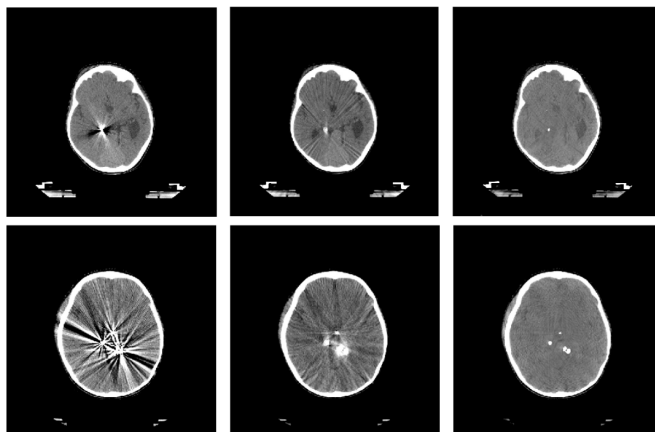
Examples of processing real corrupted CT scan with intensities in brain window (40+-80 HU). From left to right: original image, Li-MAR output, output of proposed solution. Each row corresponds to the different patient.
